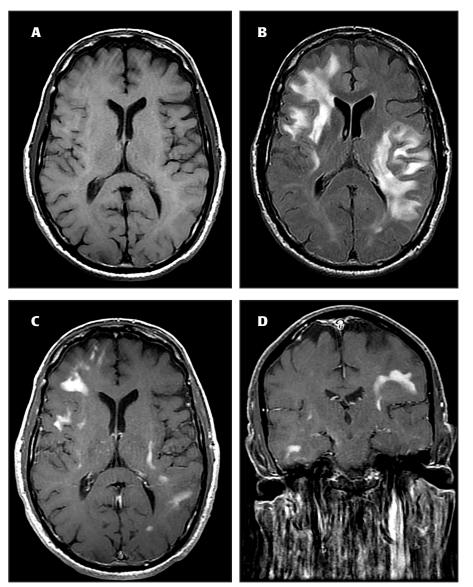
Precontrast axial T1-weighted (A) and FLAIR (B) images, and postcontrast axial (C) and coronal (D) T1-weighted images of the head.
